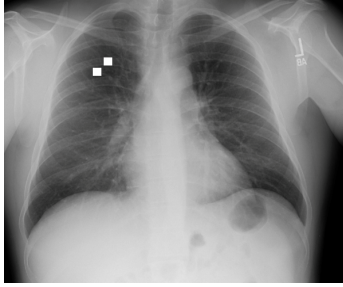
Clinical lung x-ray with ROI between upper lung and adjacent rib shadow. A dataset of six such, deidentified images were obtained from the Massachusetts General Hospital.
